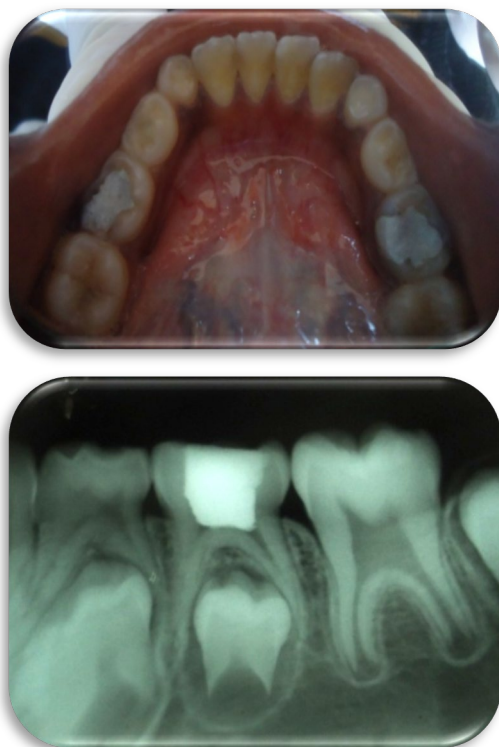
9th & 12th month follow-up-clinical and radiographic picture
